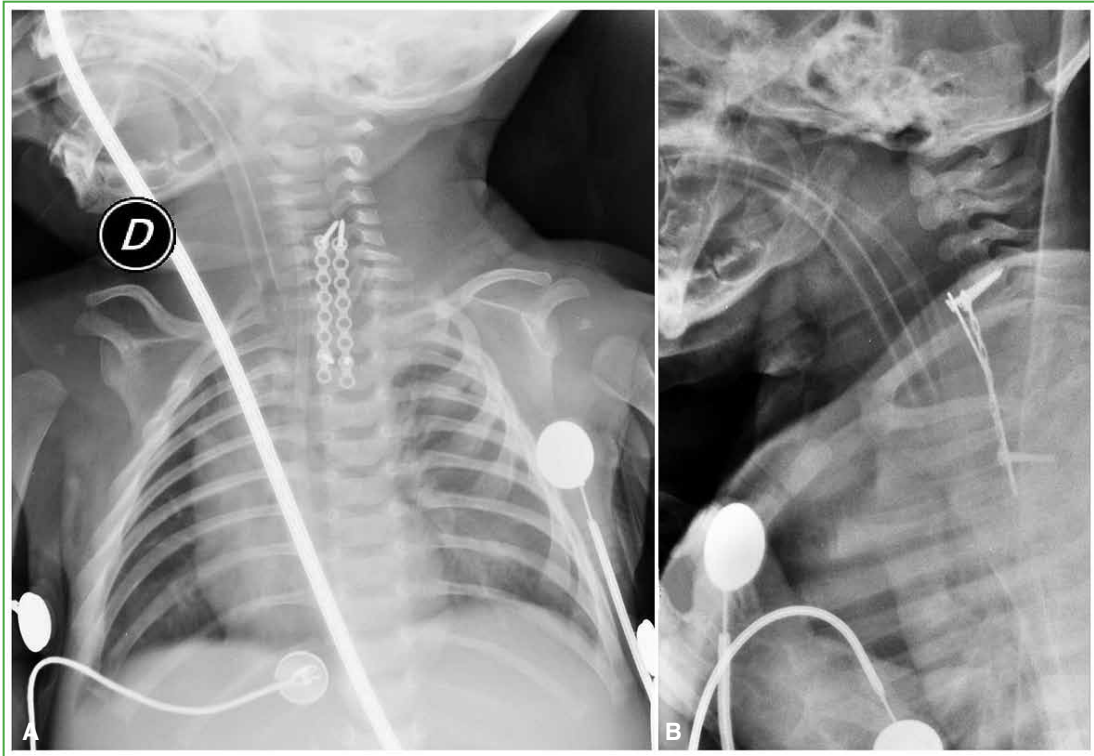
Anteroposterior (A) and lateral (B) radiographs of the cervico-thoracic spine in the immediate postoperative period in the Neonatal Intensive Care Unit. Note the adequate placement of the osteosynthesis elements.
